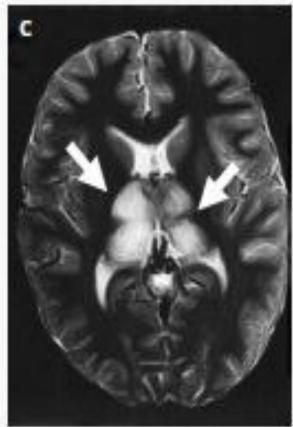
T<sub>2</sub>-Weighted Magnetic Resonance Images Showing High Signal Intensity and Swelling in the Thalamus (Arrows) of Patients with Japanese Encephalitis (Panel A), West Nile Encephalitis (Panel B), and Murray Valley Encephalitis (Panel C).
